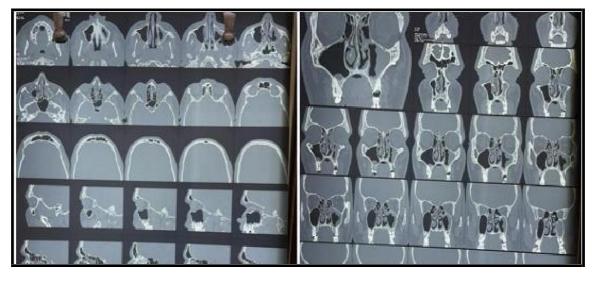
Computed tomography (CT) of the paranasal sinuses
